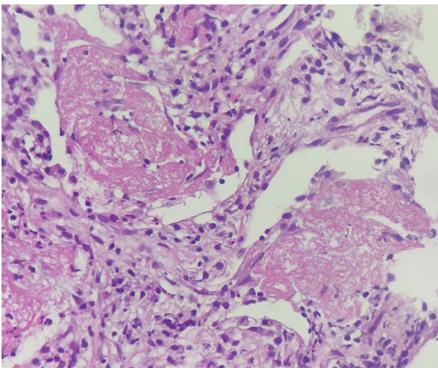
HPE of CT-guided lung biopsy (4th May 2024)—many polypoidal fibrotic plugs filling the alveolar sacs and ducts (Masson bodies) with dense interstitial fibrosis and mixed inflammatory cells
